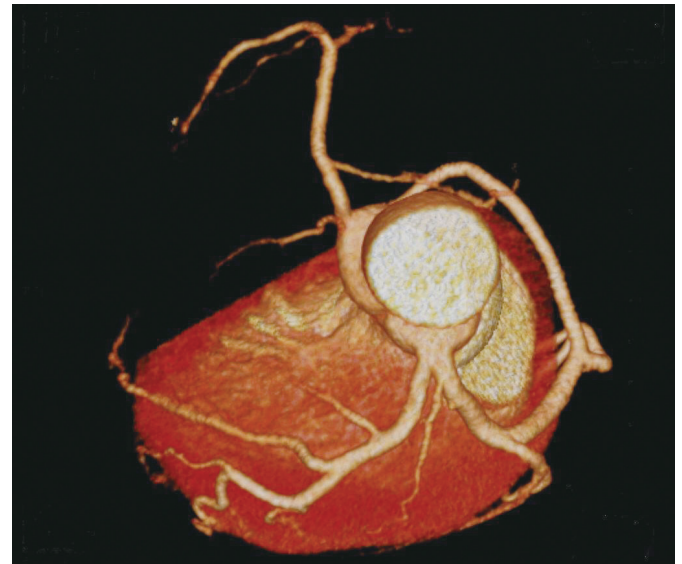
Multi-detector computed tomography shows no intraluminal narrowing in coronary artery.
